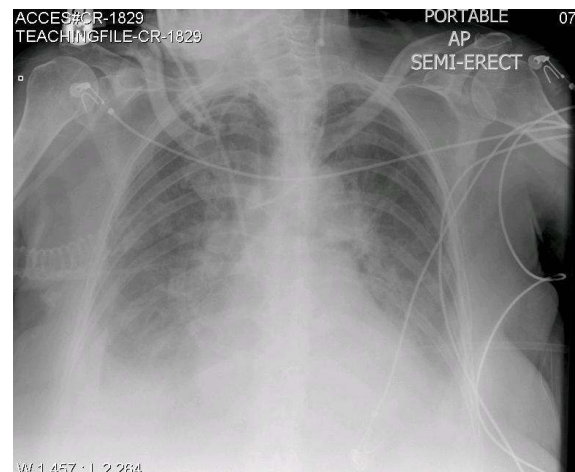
2 (CR-1829): The optimum position of the left sided IJV cannula is at or just below the level of the carina 2. This radiograph shows the comparison between the right and left sided IJV cannula in the same patient.
